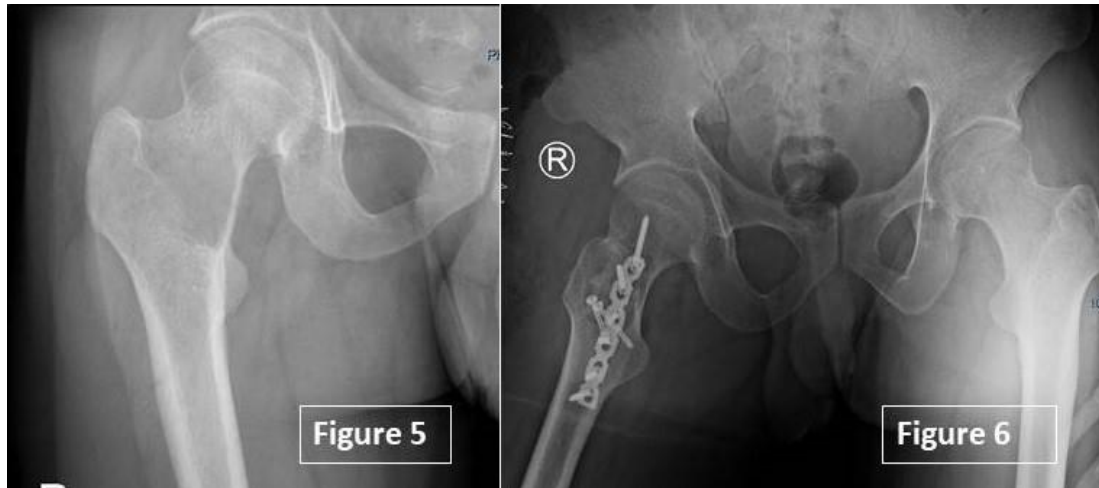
X-ray shows a right side femur neck lesion 4*3.cm size, Figure 2: postoperative X- ray show a perfect fixation.
